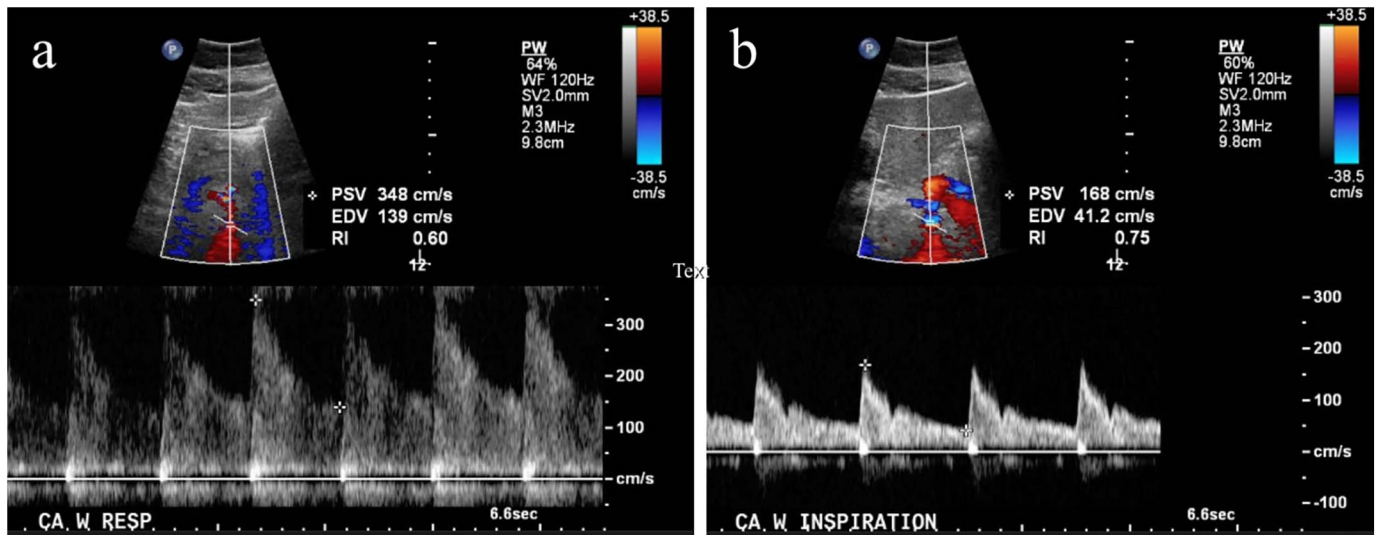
(A) Abdominal ultrasound Doppler showed a patent celiac artery with turbulent, elevated velocities of 348 cm/s in the proximal segment with normal expiration. (B) Waveforms normalized to velocities of 168 cm/s with inspiration and in the upright position.
